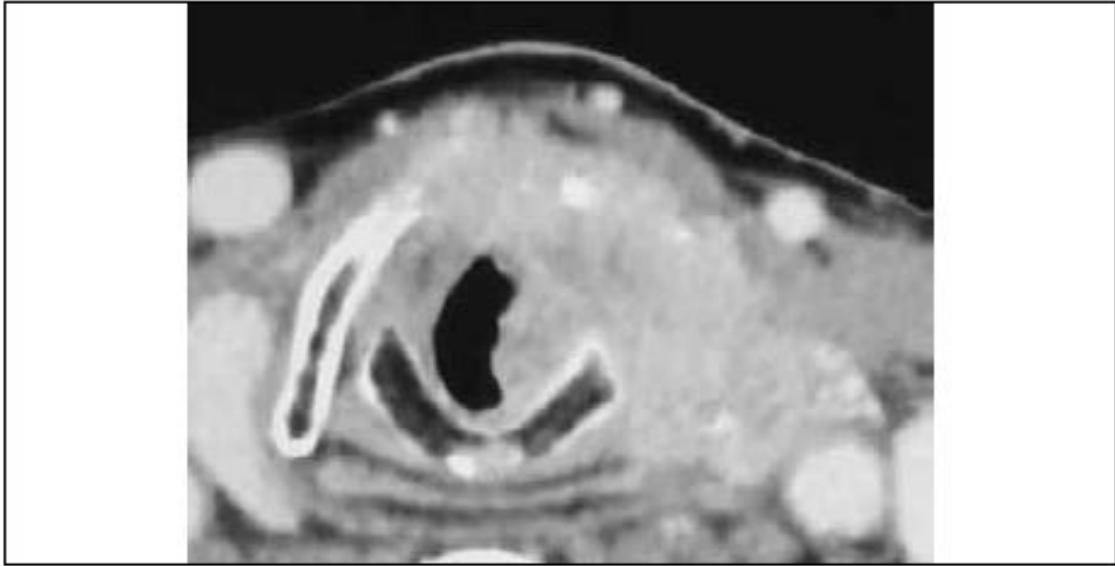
CT scan of large glottic-subglottic T4a with massive cricoid invasion and extralaryngeal spread.
